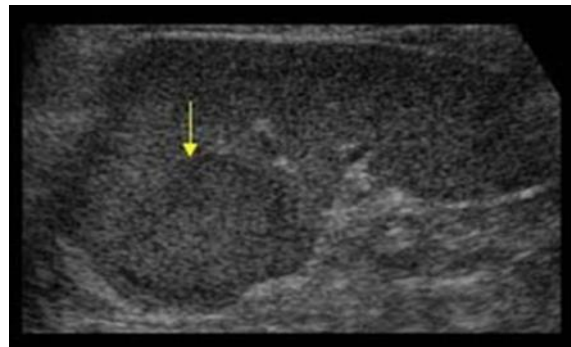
Ultrasonogram of spleen with yellow arrow pointing towards well defined demarcated highly echo dense splenic mass.
